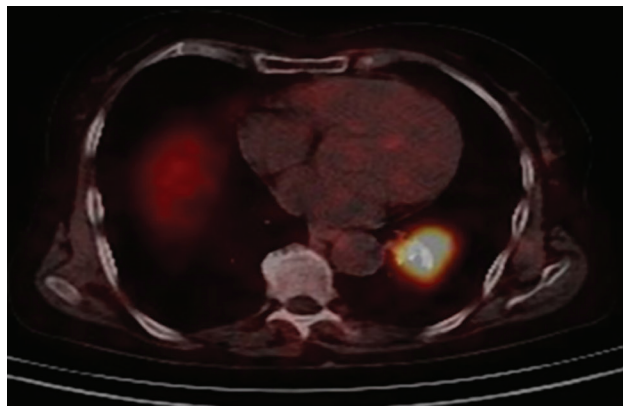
Dotatoc PET-CT showing avidity of the primary tumor in the left lower lobe (standard uptake value 15.9).
